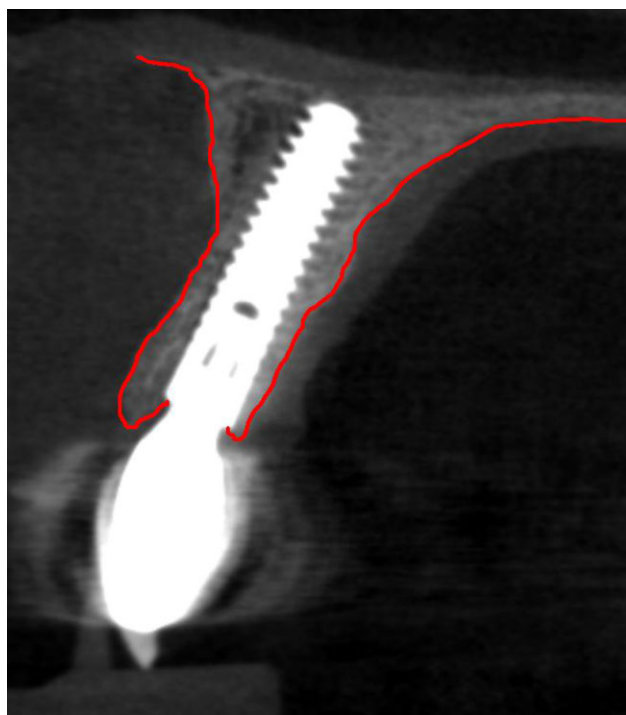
Cone beam computed tomography slide done at the 2-year follow-up.
